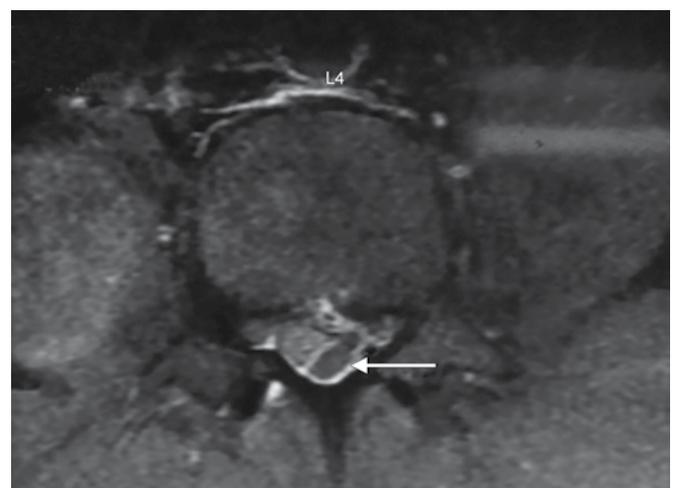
Axial MRI showing lesion on dorsolateral aspect of dural sac with mass effect
